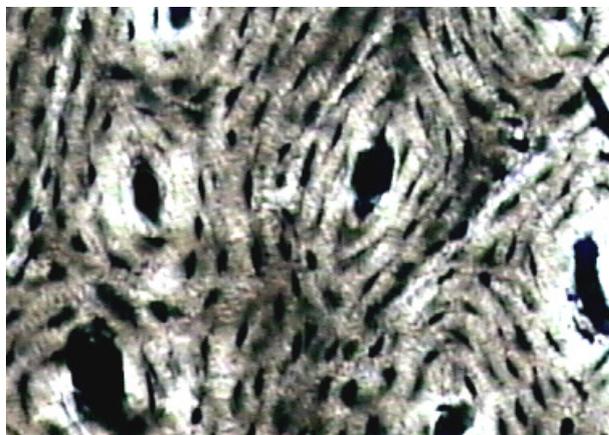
Transversal section on a segment of newly formed bone tissue after an ultrasound-stimulated fracture (polished bone, ob. ×20).
